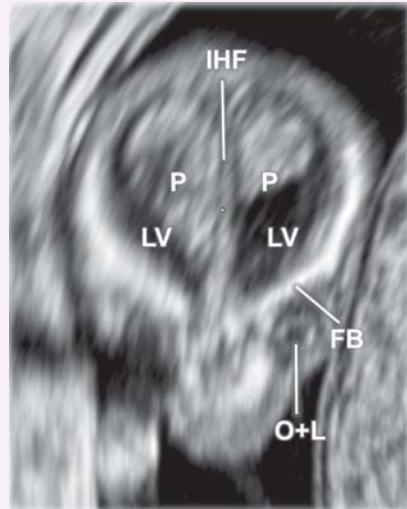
Frontal coronal view of normal fetal brain on two-dimensional ultrasound imaging at 11–13 weeks. FB, frontal bone; IHF, interhemispheric fissure; LV, lateral ventricle; O+L, eye orbit and lens; P, choroid plexus.
